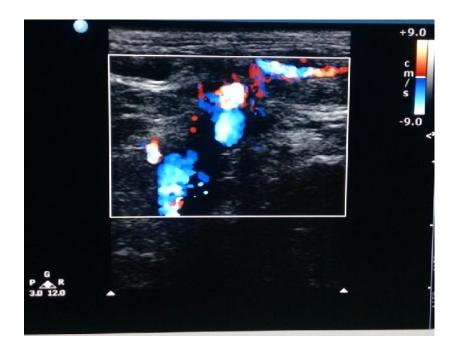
Colour Doppler USG Image showing anterior abdominal wall varices.
